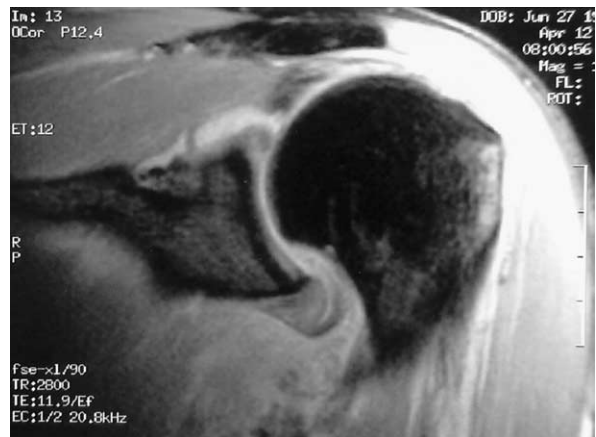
Magnetic resonance image of the rotator cuff showed a rupture of the insertion of the supraspinatus and infraspinatus tendons on the greater tuberosity.
